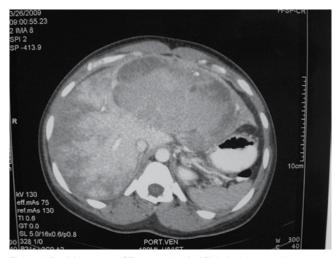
Double contrast CT scan at level of T10 showing grossly enlarged liver with a large hypoechoic lesion in the left lobe, and multiple smaller lesions in the right lobe, in keeping with metastatic disease
